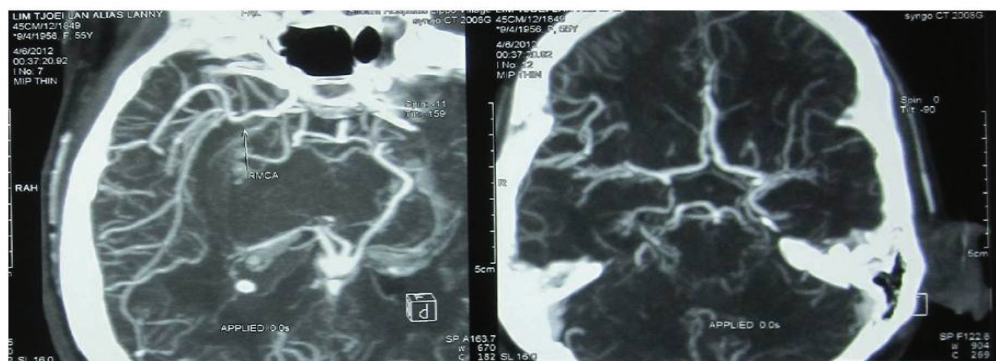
Preoperative-axial CT-angiography Shows an Aneurysm at the Posterior Cornu Wall of Right Lateral Ventricle (with Diameter ±5.6 mm)
